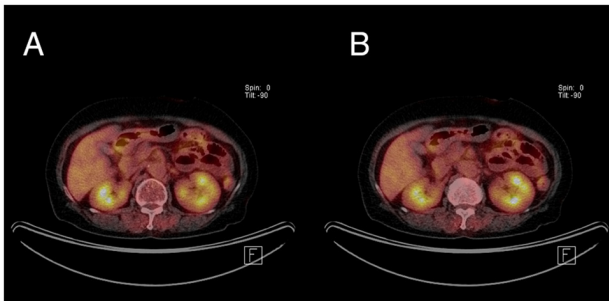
FDG PET/CT images of the SMA. (A and B) Representative FDG PET/CT images focusing on the SMA region. SMA, superior mesenteric artery; FDG PET/CT, 18F-fluorodeoxyglucose positron emission tomography/computed tomography.
